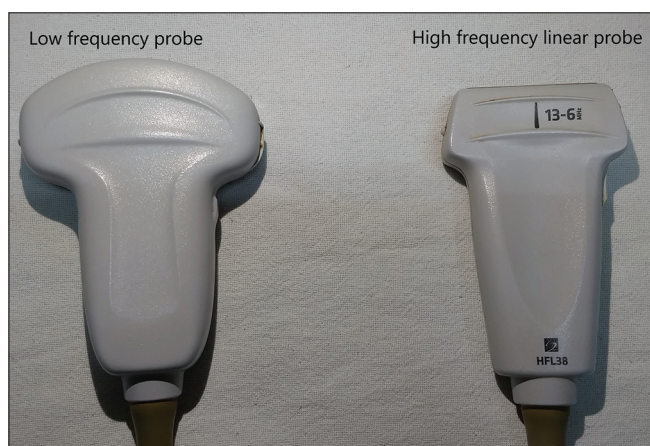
Ultrasound probes commonly used for airway management
